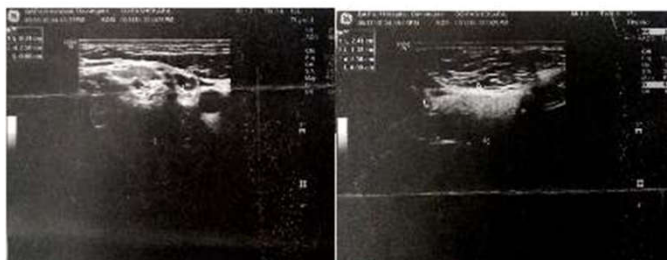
Ultrasonography of right Parotid gland shows an ill defined non encapsulated lesion with echogenicity and echopattern similar to that of fat, continuous with the adjacent subcutaneous plane and superficial parotid gland.
